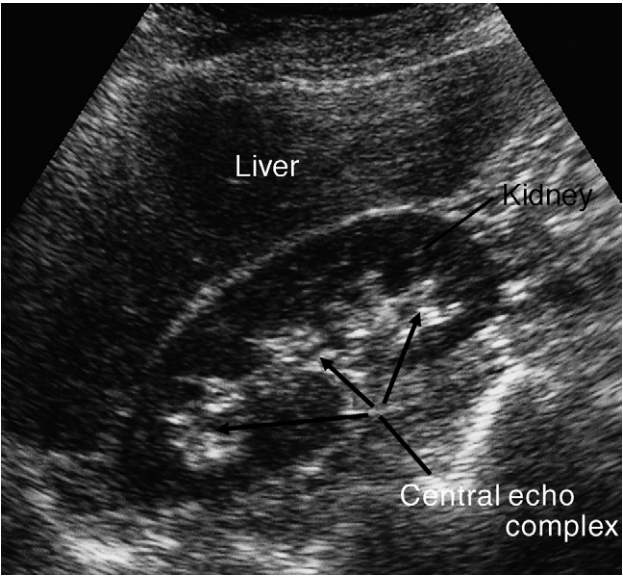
Normal ultrasound of the right kidney.
